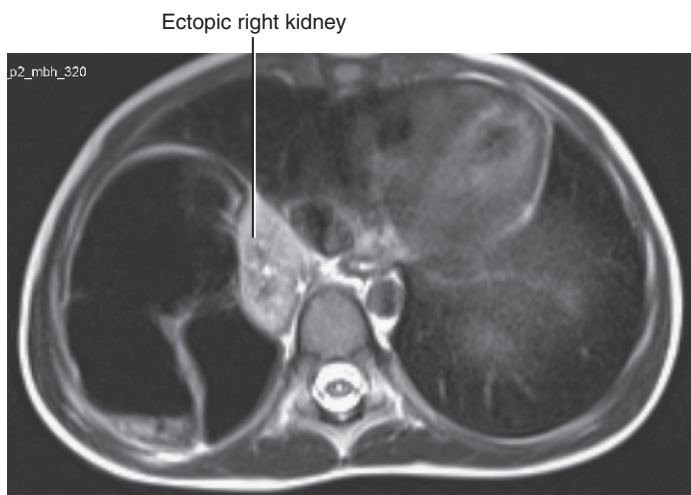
Axial T2-weighted magnetic resonance image. Same case as shown in Figure 12-17. The right kidney is in a superior location, but its exact location was not evident from this study. Surgical exploration confirmed that the diaphragm was intact; the right kidney, although located superiorly, was not intrathoracic. (Image courtesy of Nami Azar, MD.)
